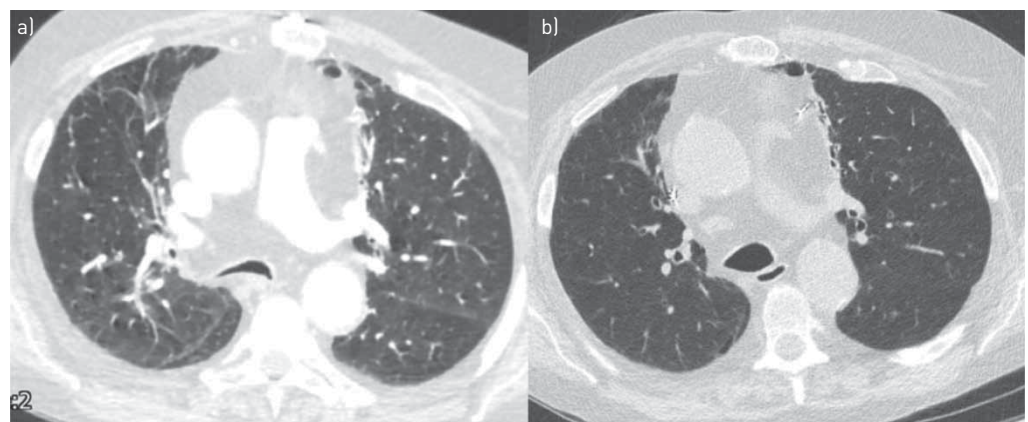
a) Patient with presentation computed tomography showing significant narrowing of trachea. b) Post-treatment imaging showing improvement in dimensions of trachea.
